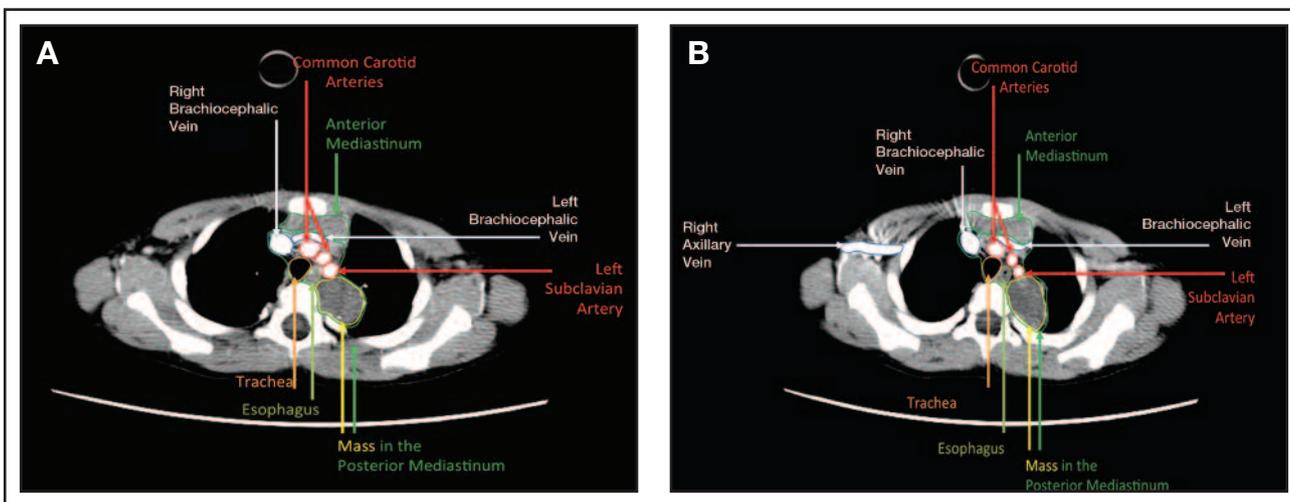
(A, B) Computed tomography (CT) of the thorax shows the presence of a mediastinal mass. Anatomic relations are indicated in the figures.
